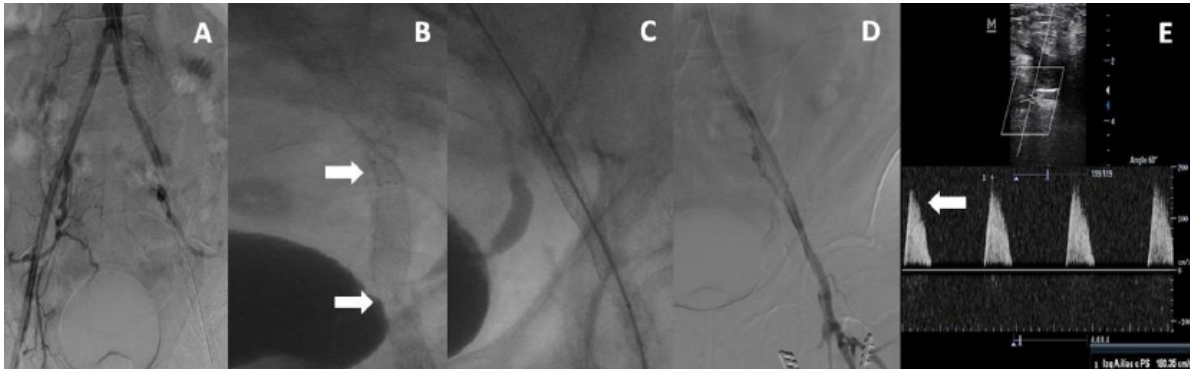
Stent collapse, final outcome, and echocardiographic follow-up. A. Left external iliac artery occlusion. B. Stent collapse (arrows). C. Complete stent deployment after balloon-expandable stent implantation. D. Complete patency of the stented segment, the left common femoral artery, and the left deep femoral artery. E. DU of the distal left external iliac artery: PSV of 180 cm/s, low-volume high-resistance waveform, and a shoulder in the systolic downstroke curve, reflecting the pulse wave from distal disease.
